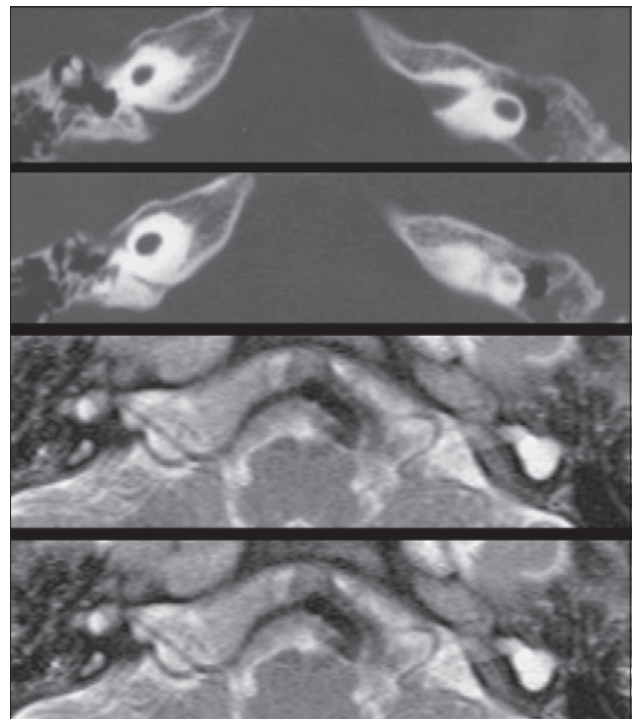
CT and MRI scans of common cavity.
